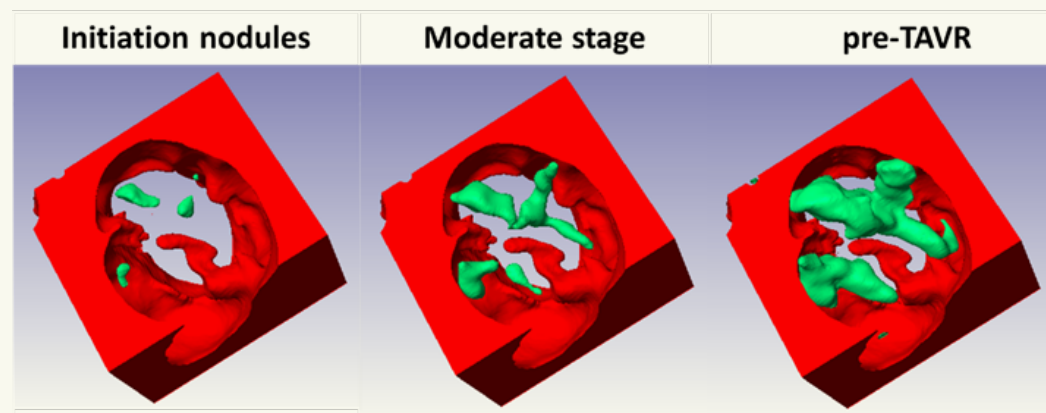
RCT of the calcified BAV patient starting from pre-TAVR CT scan.
